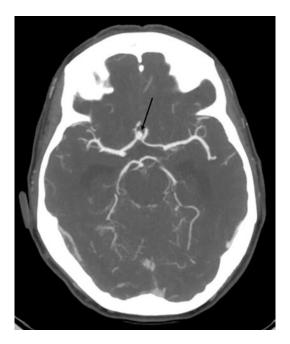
Brain CT angiogram with contrast demonstrating anterior communicating artery aneurysm (arrow)
